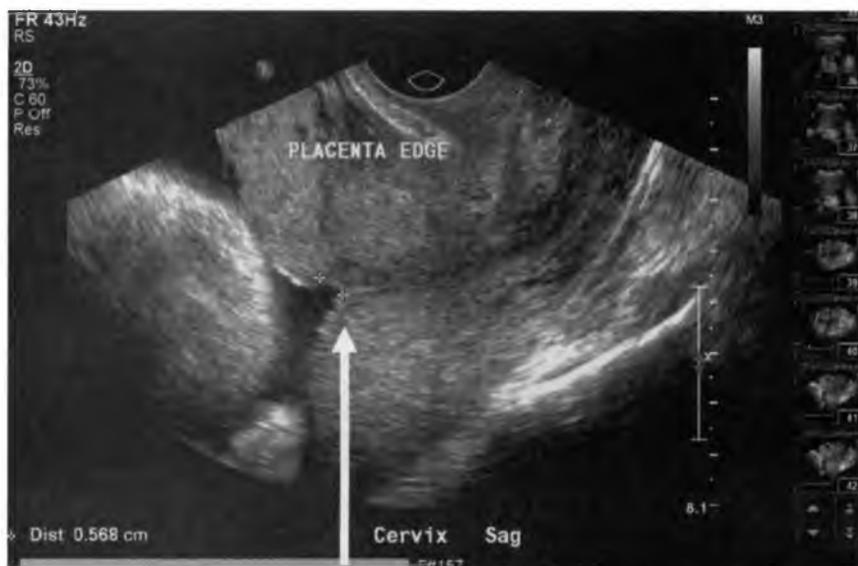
Ultrasound of placenta previa, marginal. Arrow showing placenta edge from internal os of cervical canal
